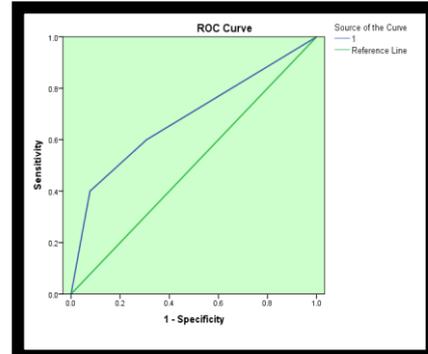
Receiver operator characteristic ROC plot: Bitewing radiograph at dentin threshold for occlusal surfaces
